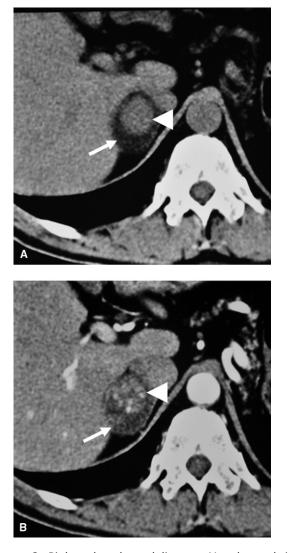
Right adrenal myelolipoma. Unenhanced (A) and enhanced (B) CT study. The tumor is well visible (A, B) as a very low-density mass (white arrow) due to the fat tissue content, whose presence is diagnostic. Within the mass, a more dense nodule is recognizable (white arrow-head), referable to the myeloid portion, with some enhancement after iodinated CA administration.
